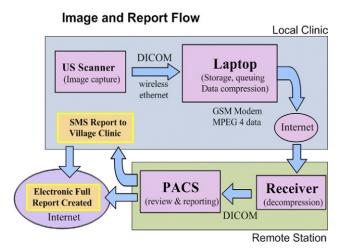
Imaging the World (ITW) data flow model for ultrasound (US) services in rural limited-resource regions showing transmission of Digital Imaging and Communications in Medicine (DICOM) images from scanner to laptop and PACS to generate report via short message service (SMS) to local clinic.
